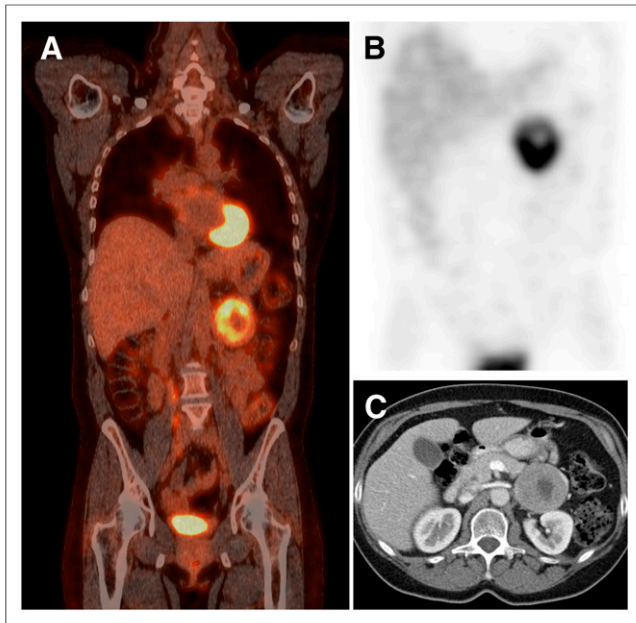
Imaging results in patient with sporadic PPGL located in left adrenal. (A) ^{18}F -FDG PET scan. (B) ^{123}I -metaiodobenzylguanidine SPECT scan. (C) CT scan.
